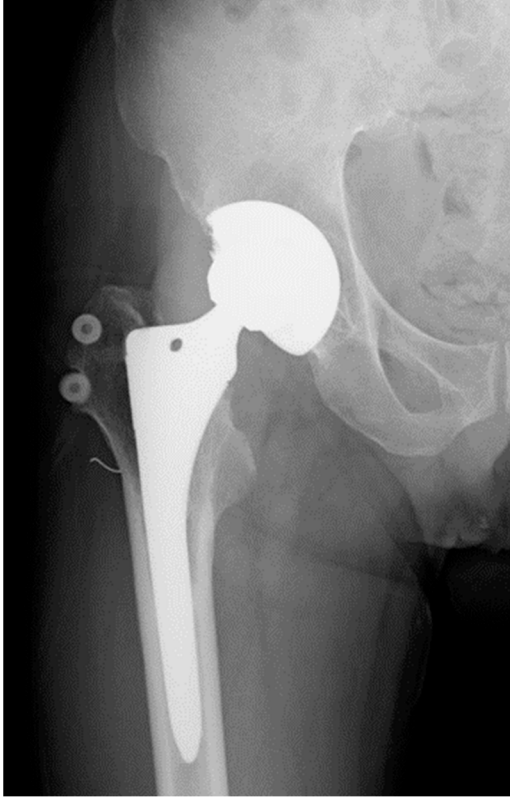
Radiographs of the right hip of a 57-year-old man.
